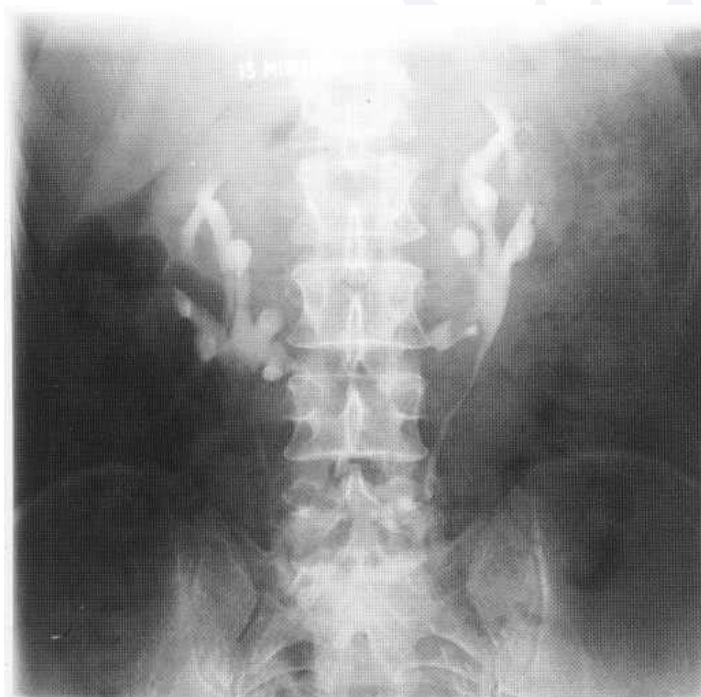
IVU (A) demonstrating a horseshoe kidney. The isthmus of fused renal tissue across the midline is well seen on CT (B).
